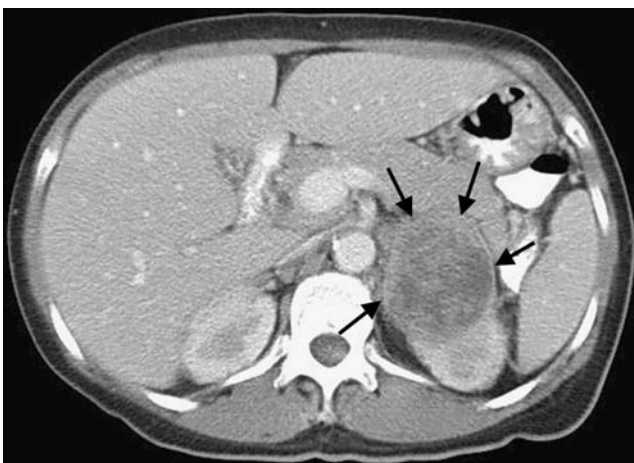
CT image at the level of the kidneys showing a mass (arrows) bulging out of the upper pole of the left kidney
